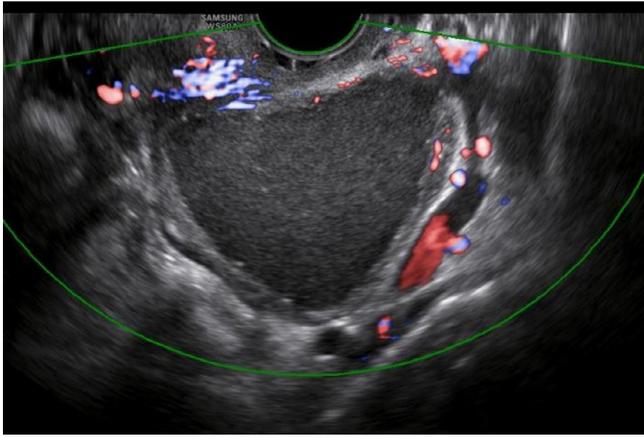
Color Doppler score of 1. There is no vascular flow noted within the unilocular cystic tumor proven to be an endometrioma.
